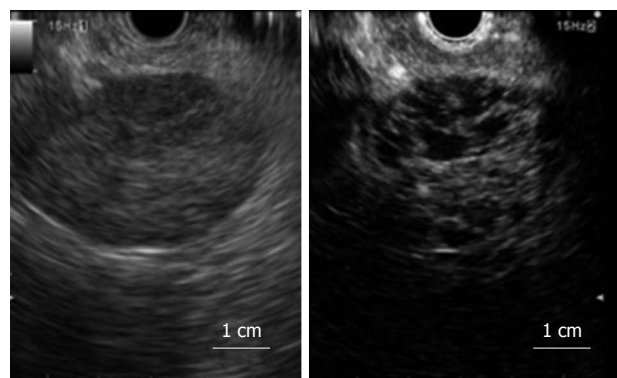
Typical example of a metastatic lymph node that shows heterogeneous enhancement on contrast-enhanced harmonic enhanced harmonic endoscopic ultrasonography (left, fundamental B mode; right, contrast harmonic mode).
